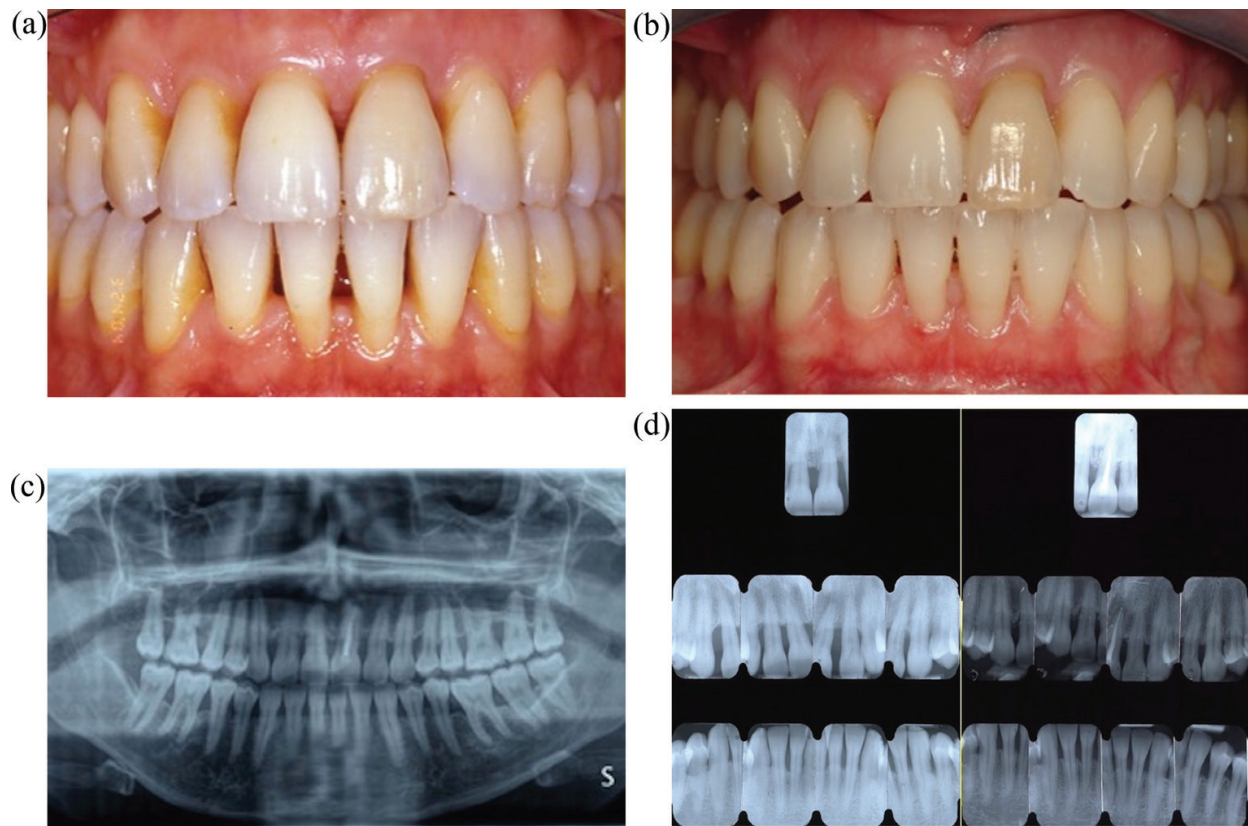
(a) Clinical check at 7 years of follow-up. (b) Clinical check at 13 years of follow-up. (c) Panoramic radiograph at 13 years of follow-up. (d) Periodontal radiographic status before the therapy and 13 years after the therapy with no fixed orthodontic retainer.
